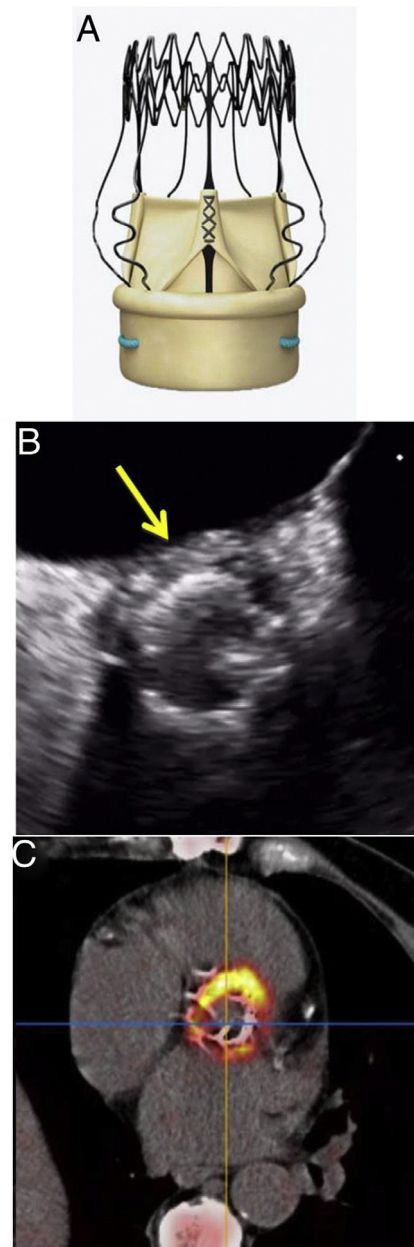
a: Perceval S prosthesis. b: transesophageal echocardiography, abscess. c: ¹⁸F-fluorodesoxyglucose positron-emission tomography/computed tomography, metabolic uptake.
